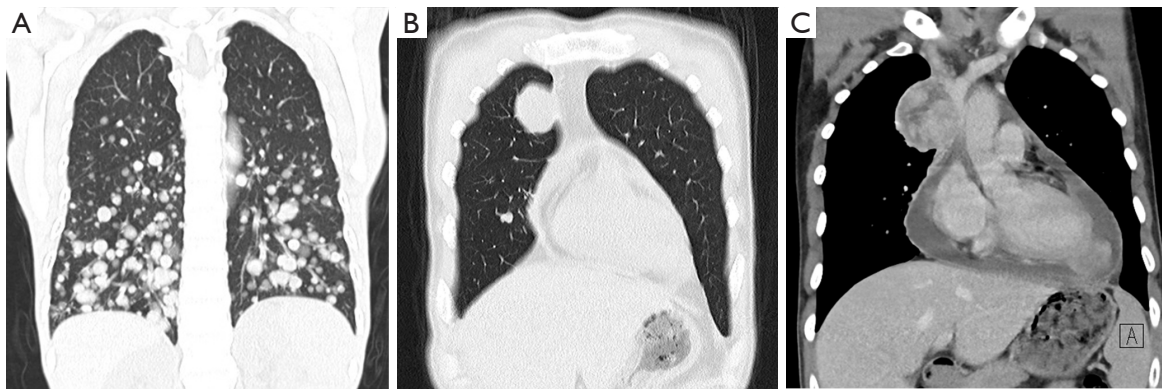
The CT images of lung metastasis. (A) Female, 48 years old, the coronal pulmonary window shows bilateral lung metastasis, predominating in the inferior lobes, at the initial visit. (B,C) Male, 30 years old: (B) the coronal pulmonary window; (C) the coronal mediastinal window in the venous phase; metastatic lung disease showed remarkable persistent enhancement. CT, computed tomography; A, anterior.
